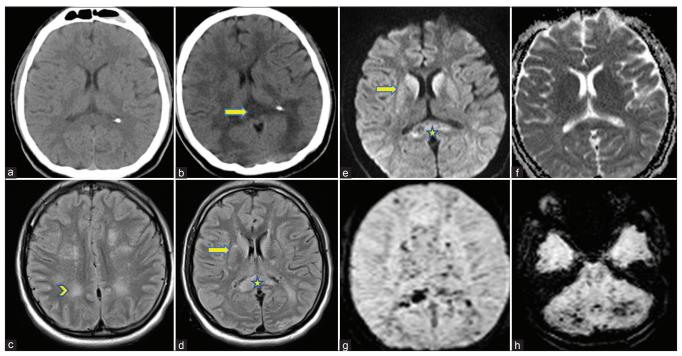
(a) Axial CT Brain at the time of admission and (b) Day 5 post-fixation, there is interval development of bilateral confluent areas of white matter hypoattenuation with mild effacement of adjoining gyri; splenium of corpus callosum (arrow) was bulky and hypodense. (c and d) Corresponding FLAIR MRI images (D12 post fixation) showing confluent high signal in forementioned areas. Also, there is diffusely increased signal of the basal ganglia (arrow). (e) DWI and (f) ADC maps suggesting diffusion restriction only in basal ganglia. The splenium shows altered signal. (g and h) SWI images show bilateral innumerable punctate round foci of hypointense blooming involving the splenium of corpus callosum, bilateral subcortical as well as cerebellar white matter.
